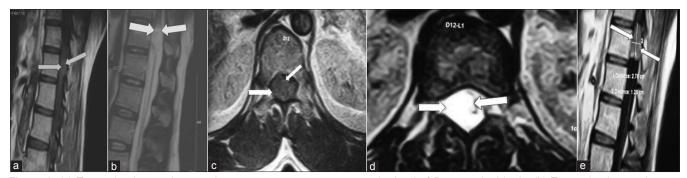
(a) T1-weighted sagittal image demonstrates isointense mass at the level of D12 vertebral body. (b) T2-weighted sagittal image demonstrates hyperintense oval nodular mass (c) T1-weighted axial image shows well-circumscribed intradural isointense mass (d) T2-weighted axial MR image demonstrates a hyperintense solid tumor on the right side of the thecal sac, causing cord compression (e) T1W sagittal MRI with gadolinium contrast showing 2.78 × 1.28 cm, well-defined and homogenously enhancing mass at the level of D12 vertebral body
